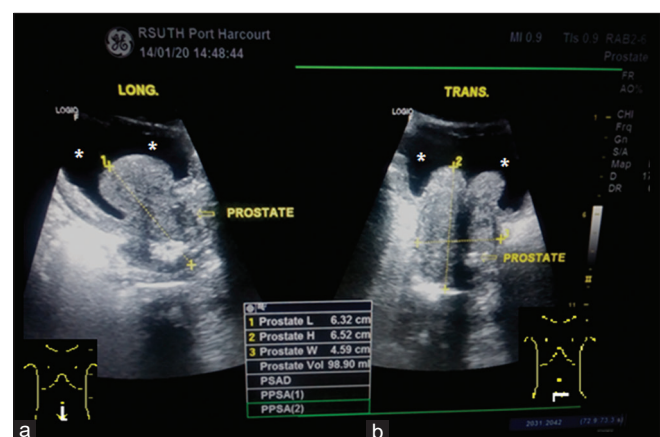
Transabdominal sonograms of a participant showing grey-scale static images of the prostate gland – Longitudinal (a) and Transverse (b) sections with a prostatic volume of 98.90cm³ NB: LONG: Longitudinal section, TRANS: Transverse section; *: Urinary bladder
